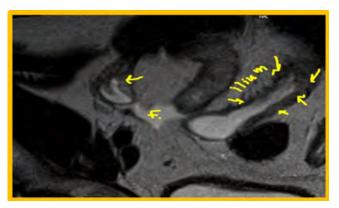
MRI STIR sequence shows: abnormal high STIR signal with fat stranding in right iliac fossa region; representing advanced inflammatory process
